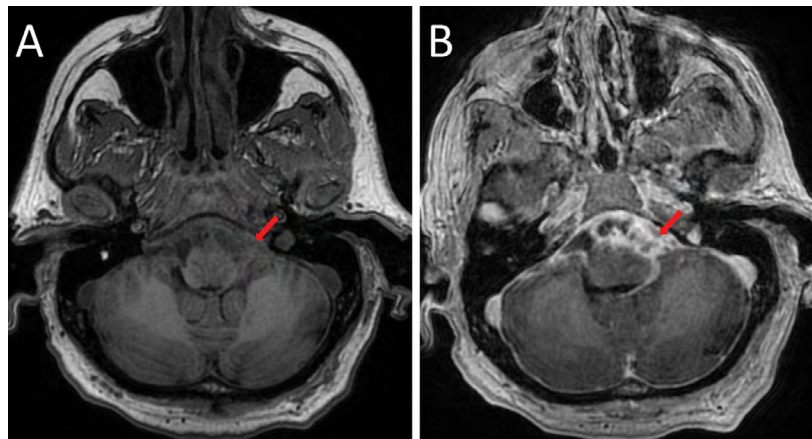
Axial T1-weighted images pre- (A) and post- (B) contrast administration demonstrating extensive, complex, multiseptated enhancement through the pre-pontine cistern and along the leptomeningeal surface of the brainstem. There is mass effect, with effacement of the ventral brain stem
